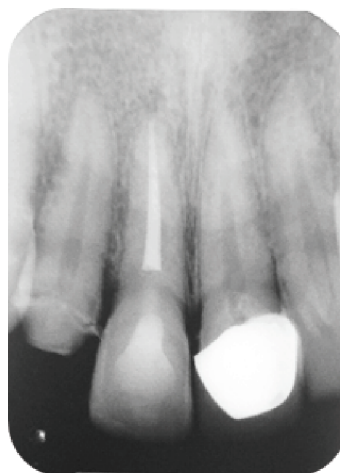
Post-operative radiograph showing final restoration. The overhanging restoration was not visible and the contact point was good.
